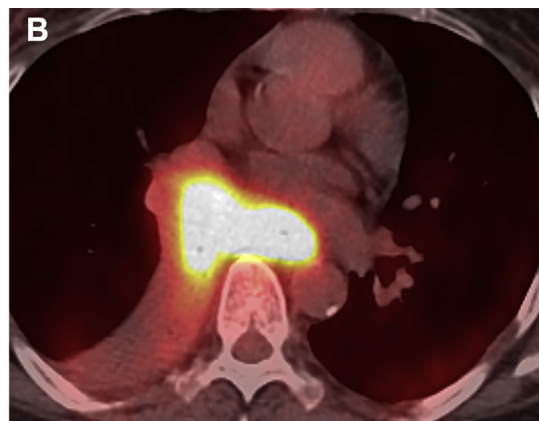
(A) Contrast-enhanced axial CT of the chest at the level of the left inferior pulmonary vein shows a poorly marginated esophageal mass (asterisk) extending into the azygoesophageal recess. The mass occludes the bronchus intermedius and results in atelectasis of the right lower lobe. (B) Fused axial FDG PET/CT at the same level confirms the findings on CT. CT is the optimal modality for detecting gross extension of the primary tumor into the adjacent structures. (Courtesy of Kelly Kage, MFA, CMI, UT MD Anderson Cancer Center, Houston, TX; with permission.)
